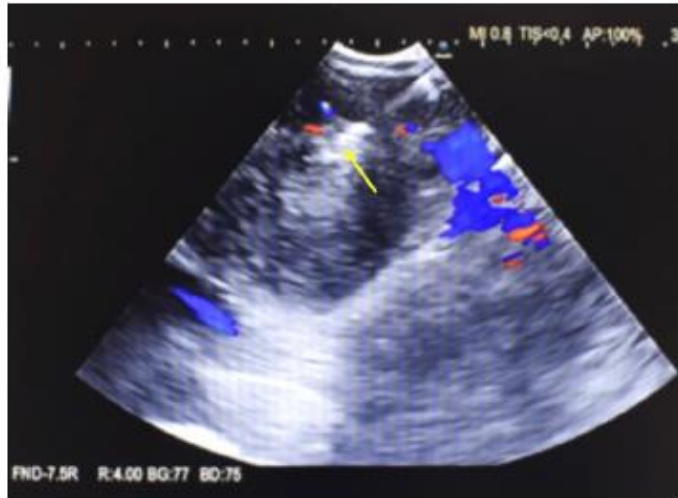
Arrow in the ultrasound image and Doppler mode pointing the tip of the cryoprobe in the correct and desired position.
